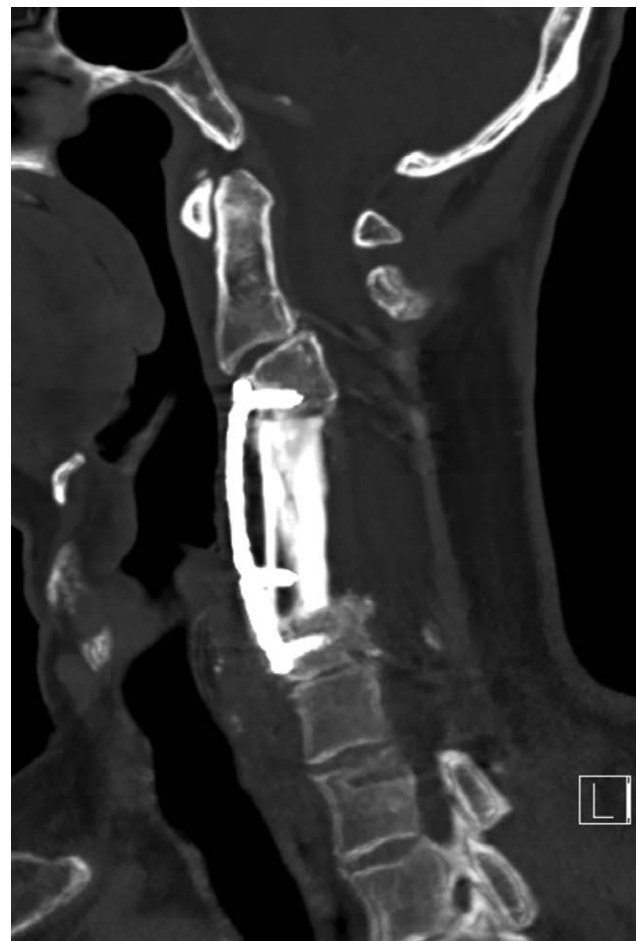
The CT scan image showing the sagittal projection of the FVFG fixated with the anterior and posterior plate at 5 months.
